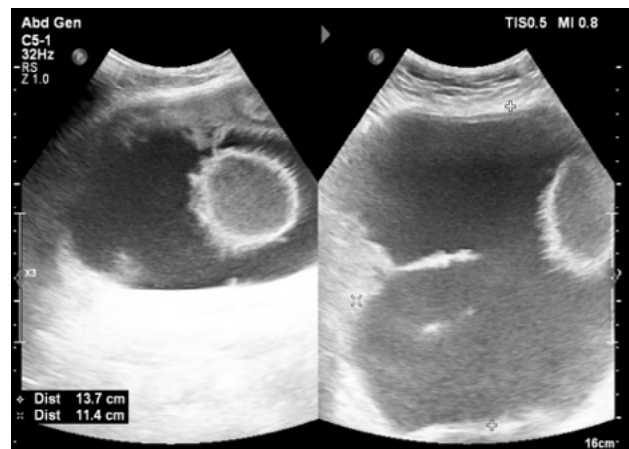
Ultrasound data of the cyst
